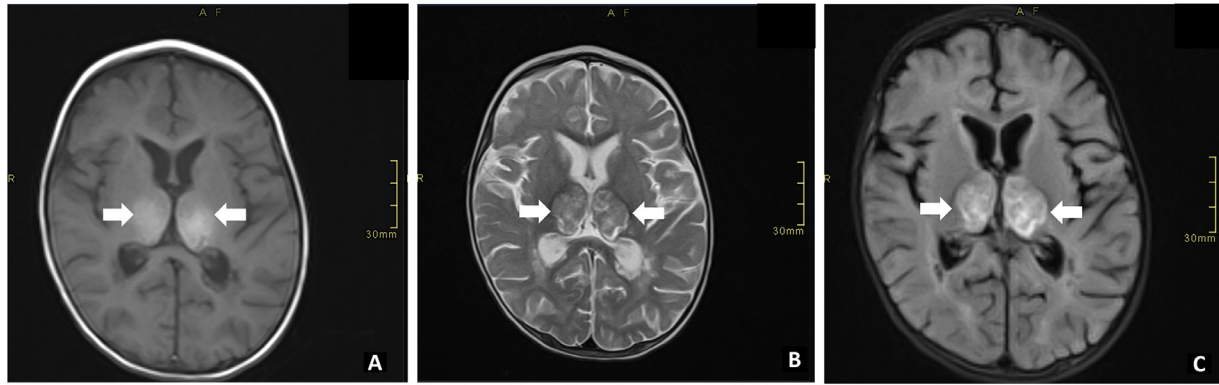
Unenhanced axial brain MRI images T1W (A), T2W(B) and FLAIR (C) show bilateral abnormal signal intensities involving both the thalami which appear relatively symmetrical. The signals appear hyperintense on T1W, heterogeneously hypointense with areas of hyperintensity on T2W and hyperintense on FLAIR (Arrows).
